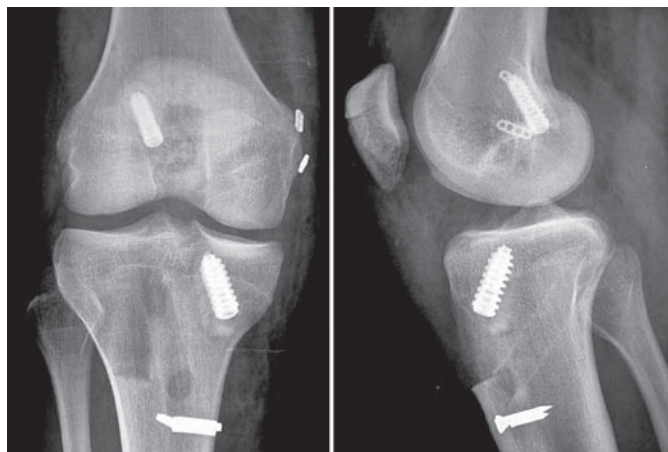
AP and lateral Radiographs in the postoperative period of the right knee.
